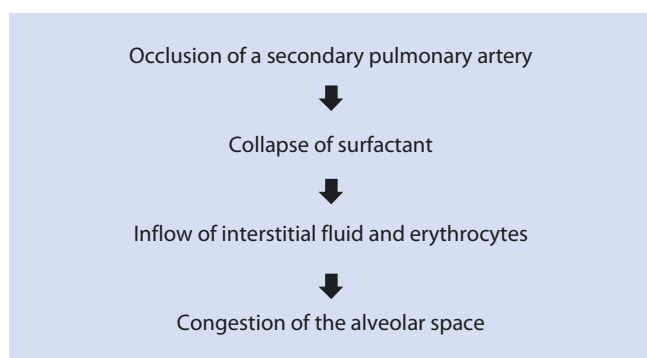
Pathophysiological prerequisites for sonographic imaging in cases of pulmonary embolism. Peripheral engorgement of the alveolar lumen is a good prerequisite for pathological echo transmission
